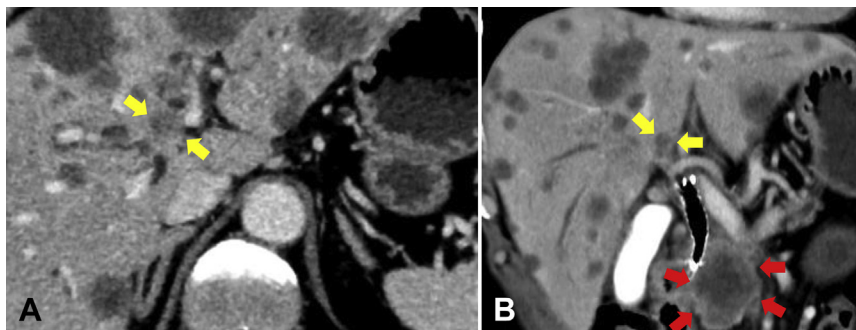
Abdominal CT images show a pancreatic mass (red arrows) and dilated intrahepatic bile ducts owing to a metastatic hilar liver tumor (yellow arrows).
